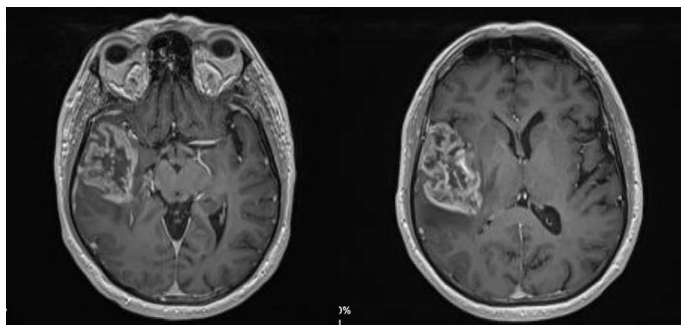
Pre-operative MRI of the brain
